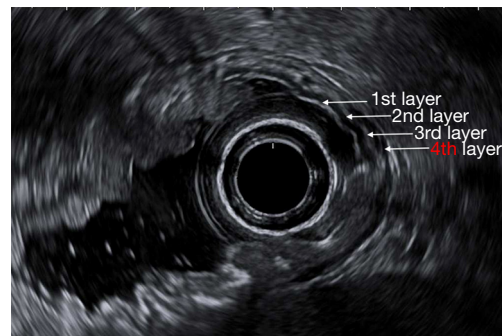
EUS depiction of gastric layers. Layer 1: mucosa; layer 2: muscularis mucosa; layer 3 submucosal; layer 4: muscularis propria. EUS, endoscopic ultrasound.
